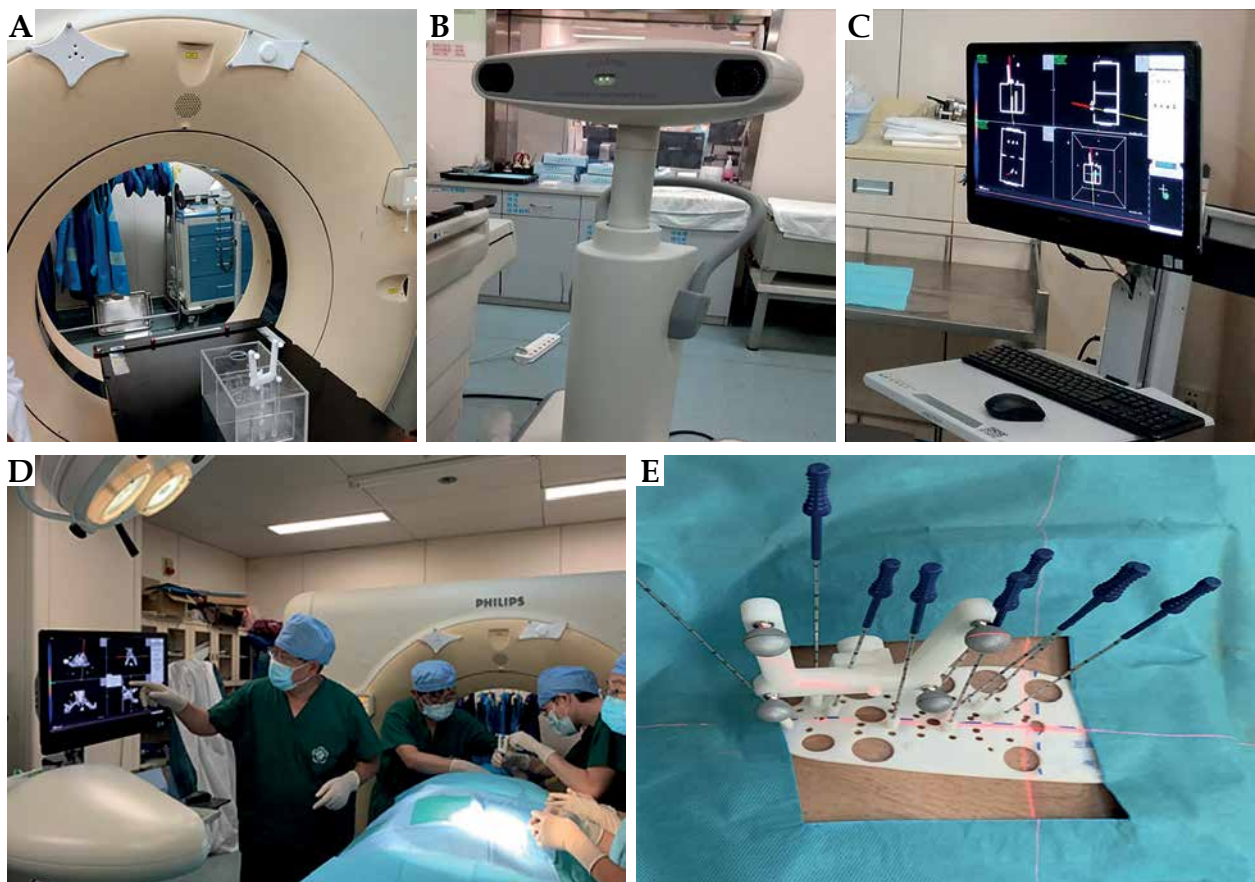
Image navigation system composition. A) CT locator and optical tracer for needle position; B) Optical sensing device; C) Image registration and real-time display system; D, E) Real-time operator-guided surgery
